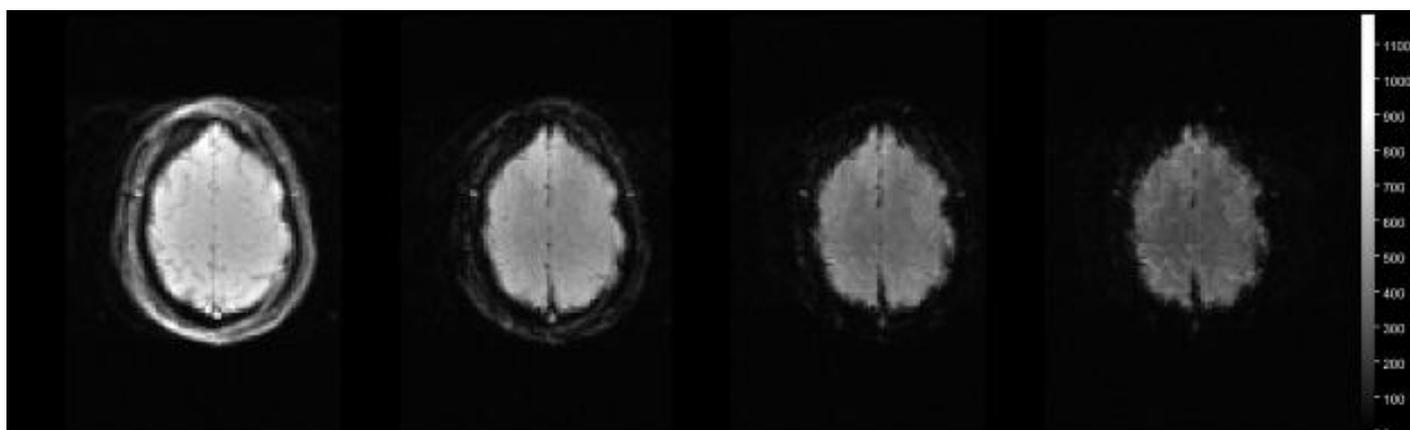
With increasing echo-time the image contrast becomes more T2\*-weighted. The set of four images (TE=9.5/15.4/21.3/27ms) is acquired within TA<1.4s (for multiple slices) making dynamic MRI over a volume of interest possible.
